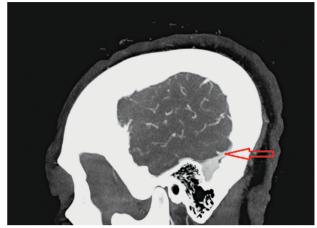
Images of patient with IHH. A) Non-contrast CT sagittal reformatted image showing positive VAS. B) This is proved on the post-contrast CT study (red arrows).
